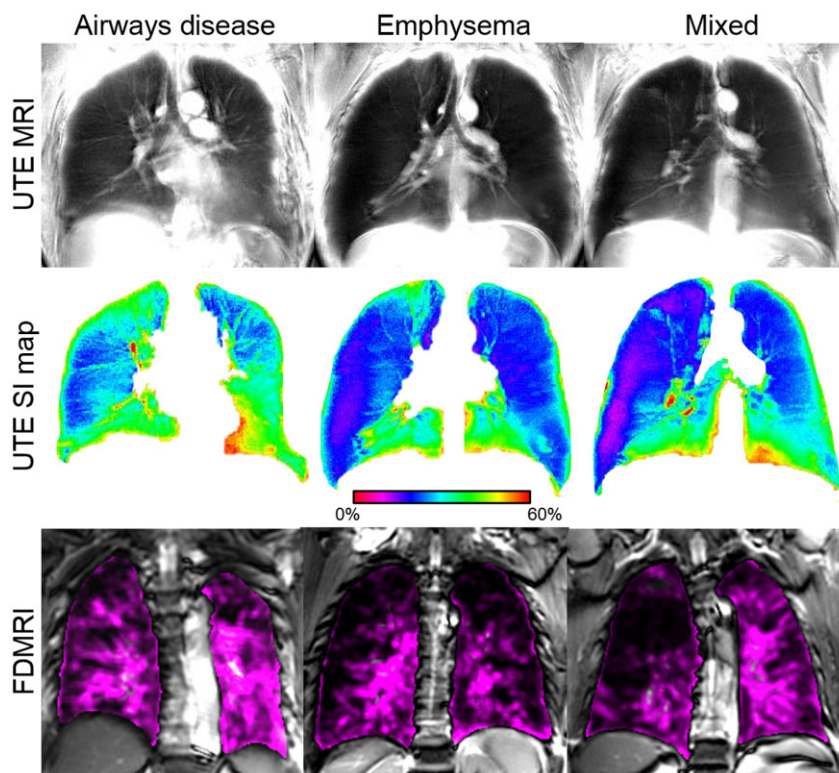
^1H MR images acquired using fast recalled gradient echo (FGRE), ultra-short echo time (UTE) and Fourier Decomposition MRI of subjects shown below. From left to right: airways disease dominant, emphysema dominant and mixed phenotype. Airways disease dominant: $\text{FEV}_1 = 89\%_{\text{pred}}$, $\text{DL}_{\text{CO}} = 64\%_{\text{pred}}$, $\text{RA}_{950} = 2\%$, ^1H UTE signal-intensity = 29%; Emphysema dominant: $\text{FEV}_1 = 28\%_{\text{pred}}$, $\text{DL}_{\text{CO}} = 32\%_{\text{pred}}$, $\text{RA}_{950} = 37\%$, ^1H UTE signal-intensity = 22%; Mixed: $\text{FEV}_1 = 52\%_{\text{pred}}$, $\text{DL}_{\text{CO}} = 55\%_{\text{pred}}$, $\text{RA}_{950} = 28\%$, ^1H UTE signal-intensity = 22%.
